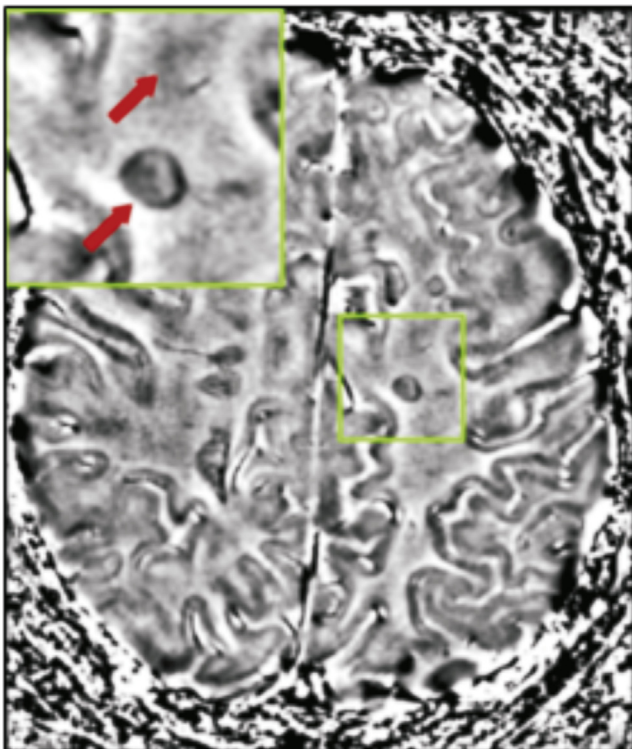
MRI technique showing an iron deposit in a white matter lesion (inside green box in the middle of the image [53]. https://en.m.wikipedia.org/wiki/Multiple_sclerosis).
